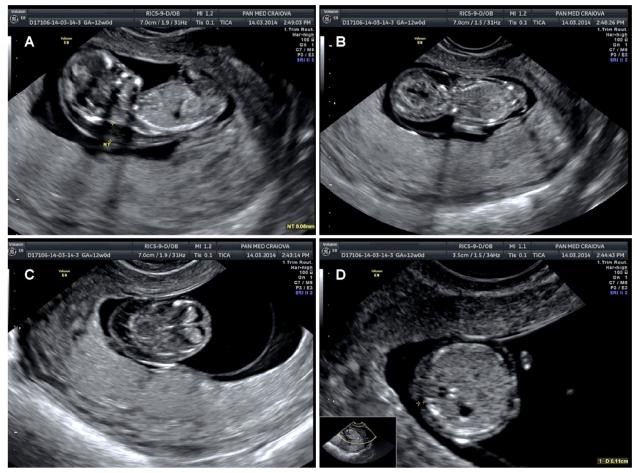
Ultrasound images on the first fetus with cystic hygroma: (A) Sagittal view, NT 5.06 mm; (B) Frontal view – CH can be observed, predominantly developed on the left part of the neck; (C) Head, transversal section – detail of multi thin-septated CH, especially on left side; (D) Abdominal transversal section – the subcutaneous edema can be observed (1.1 mm), especially affecting the anterior wall. CH: Cystic hygroma; NT: Nuchal translucency.
